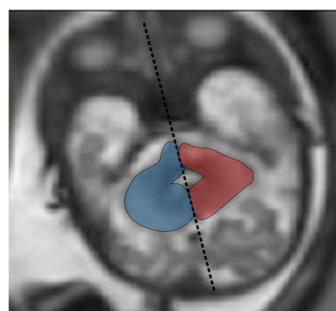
Axial slice of HR MRI image of fetus with cerebellar hypoplasia at 33.5 weeks of GA.
